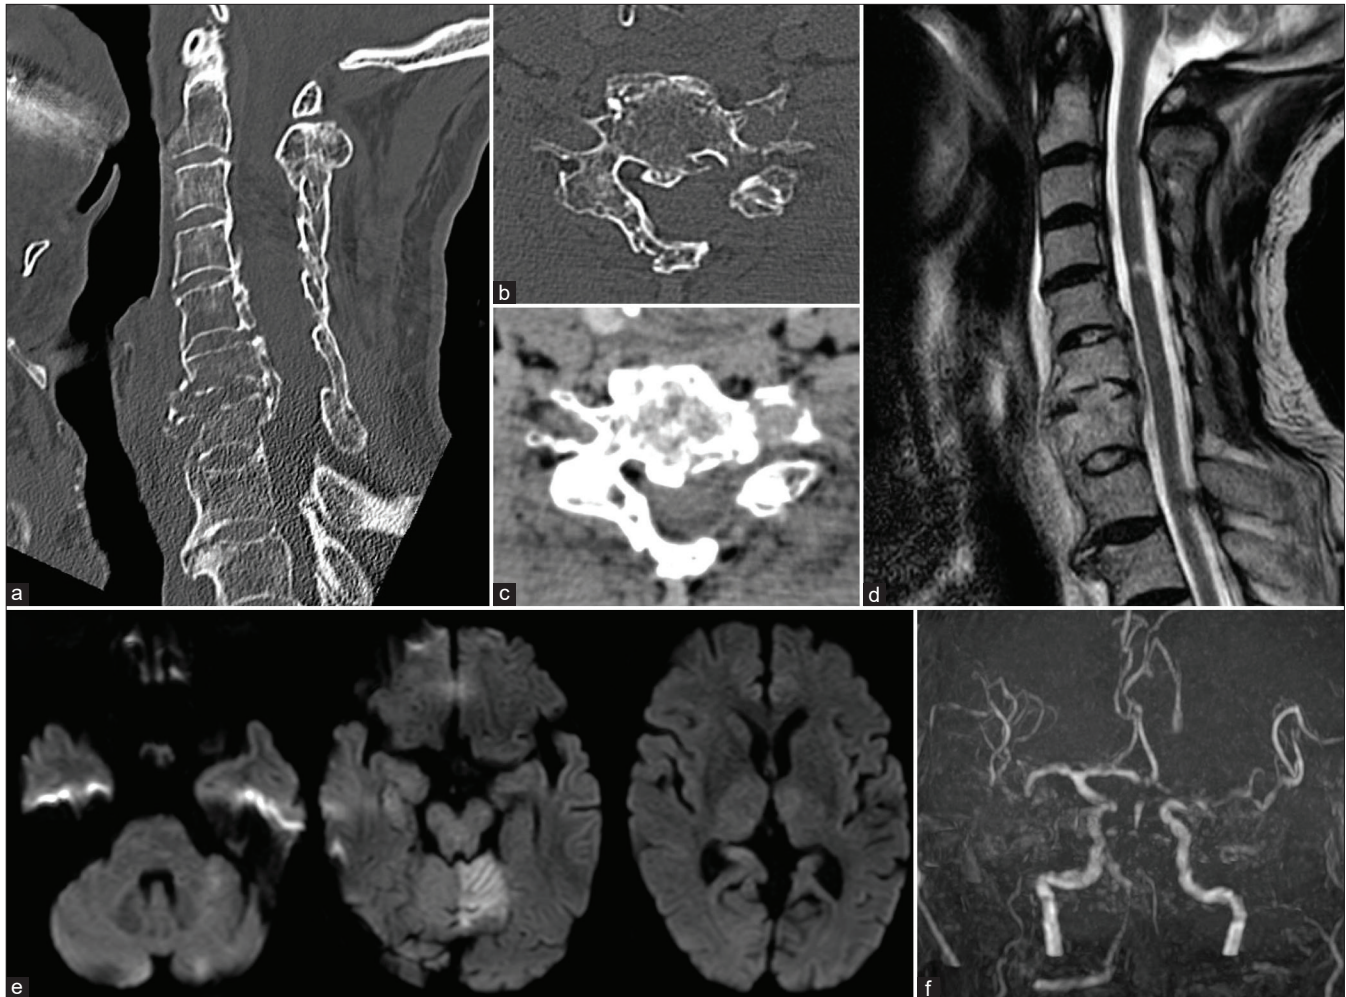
Images taken at the previous hospital: (a) the sagittal section of cervical computed tomography (CT) shows vertebral fractures of the 6th and 7th cervical vertebrae and ossification of the posterior longitudinal ligament at the level of the 4th–7th cervical vertebrae. (b and c) The axial section of cervical CT at the level of the 6th cervical vertebra shows a fracture of the left transverse process and a slightly high-density area within the left transverse foramen. (d) Cervical spine T2-weighted magnetic resonance imaging shows no signs of compression of the spinal cord and a hyperintense area at the level of the 4th/5th cervical vertebrae. (e) Diffusion-weighted imaging at the time of loss of consciousness shows a slightly high-intensity area in the left cerebellum (posterior circulation acute stroke prognosis early CT score 9 points). (f) Magnetic resonance angiography at the time of loss of consciousness shows occlusion of the left vertebral and basilar arteries.
